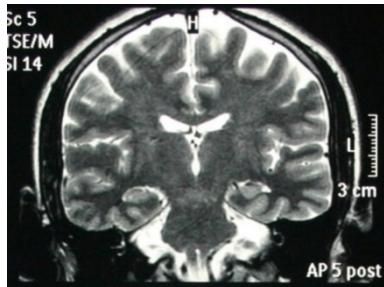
MRI on T2-weighted coronal sections, elongation of vertebral artery and compression of eighth cranial nerve as it exits from brainstem.
